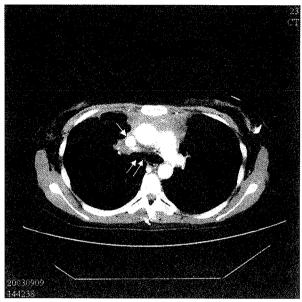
Chest CT scan, performed two weeks after chemotherapy, reveals a mediastinal tumor (\*), marked narrowing of the lower trachea and bilateral main bronchi (double arrow), a nearly totally obliterated SVC (arrow), and a tumor-invaded and collapsed RUL. The demarcation of the tumor and collapsed RUL cannot be identified clearly. There is a small amount of left-sided pleural effusion.
